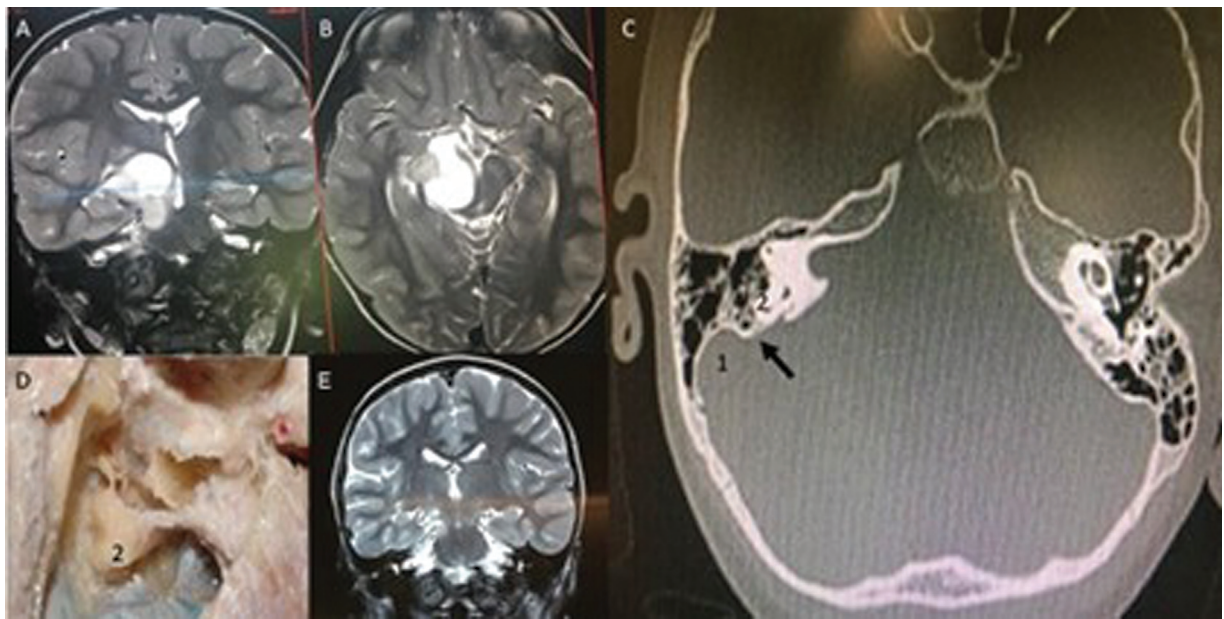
Thalamic tumor. (A) coronal T2-weighted image showing cystic thalamic tumor; (B) axial T2-weighted image, same tumor; (C) axial computed tomography of the head bone window. A posterior petrosal approach is a possibility. However, in pediatric patients, the space between the sigmoid sinus (1) and the posterior semicircular canal (2) can be too narrow. Based on that, it was performed a transmiddle temporal gyrus approach with near total resection of the lesion and no postoperative deficits; (D) mastoid dissection showing the posterior semicircular canal; (E) coronal T2-weighted postoperative image
